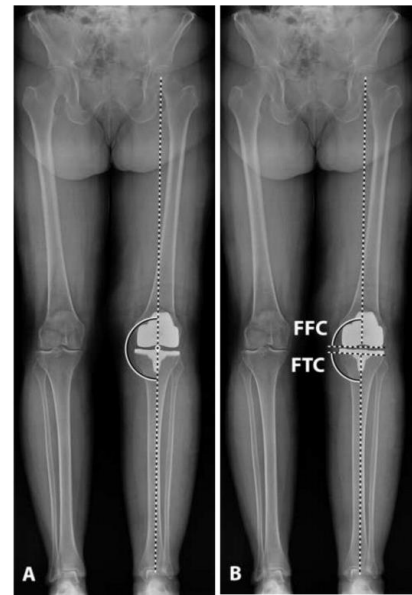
Standing coronal radiographs after total knee replacement was conducted assisted by patient specific instrumentation. (A) Measurement of the limb mechanical axis, (B) measurement of the femoral component (FFC) and the frontal tibial component (FTC) to determine varus/valgus alignment [42]
